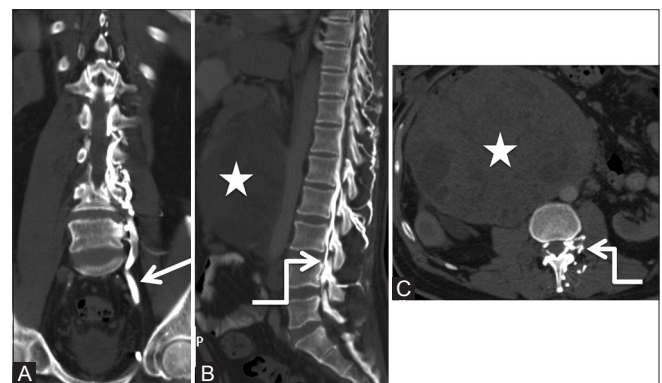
(A-C): Miscellaneous: Collateral venous pathway: Coronal (A), sagittal (B), and axial (C) Computed tomography scan images of the abdomen showing dilated ascending lumbar vein (arrow), anterior, and posterior epidural plexuses (elbow arrow) due to the chronic obstruction of inferior vena cava caused by metastatic retroperitoneal lymphadenopathy (star) from seminoma in a 50-year-old patient
